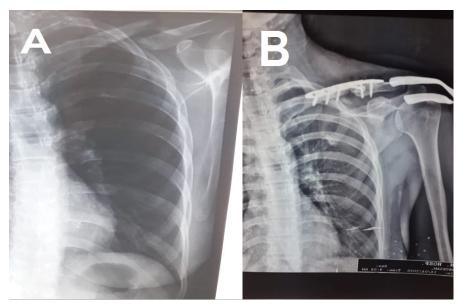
Patient no. 4 with Lt clavicle atrophic non-union preoperative X-ray; A. Pre-operative X-ray; B. Emerge post-operative X-ray showing fixation with 5 screws on either side of the fracture
